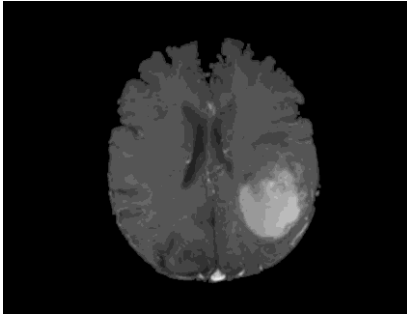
Skull stripping of MRI image.
